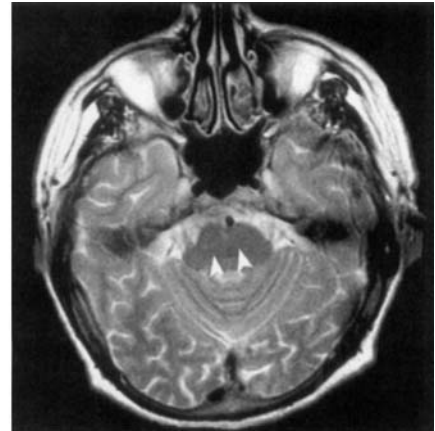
Cerebral magnetic resonance imaging: normal (see white arrows)
